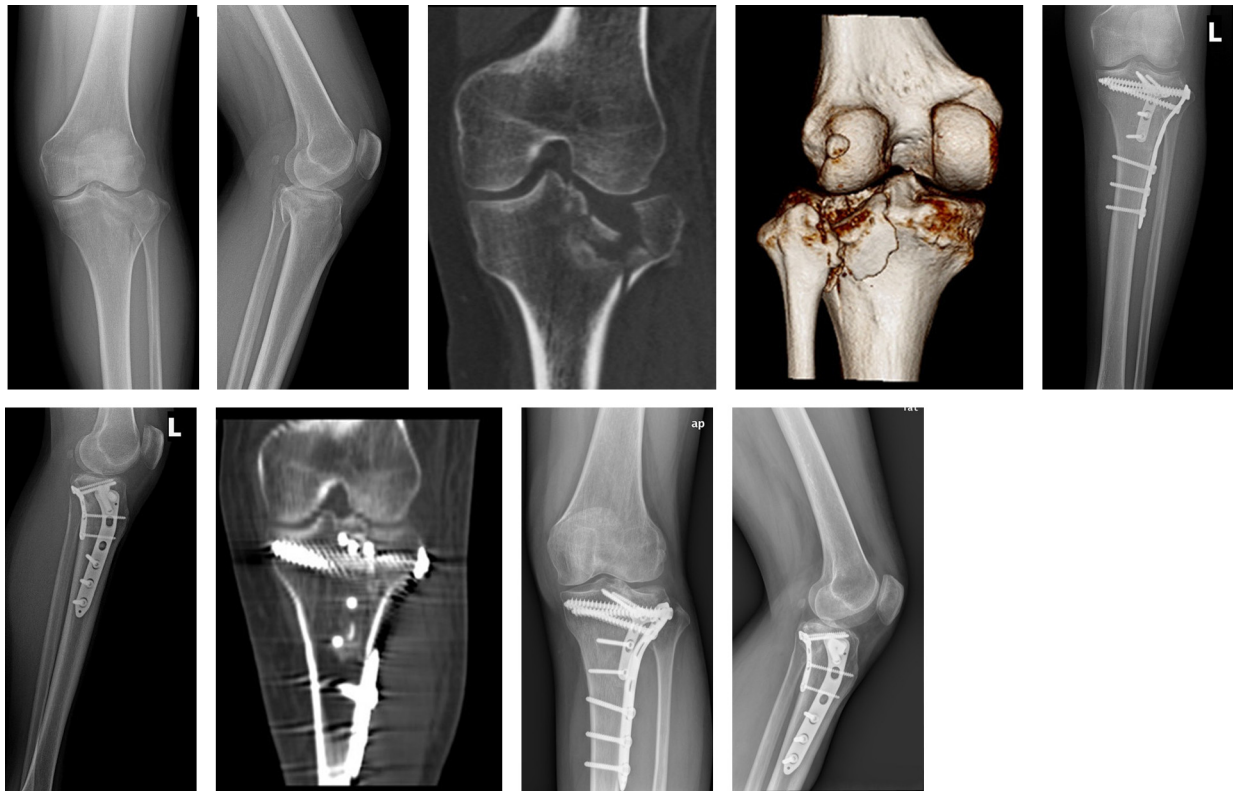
A 38-year-old woman had left-sided tibial plateau fractures after high energy trauma. Her preoperative anteroposterior radiograph and CT show (a–d) that the tibial plateau fractures involved lateral and posterolateral column. This case was treated with dual plates through the combined approaches included a conventional anterolateral approach and an inverted L-shaped posterolateral approach (e–g). Follow-up anteroposterior radiograph after 1 year shows complete union of fracture (h, i). The clinical outcome was excellent.
